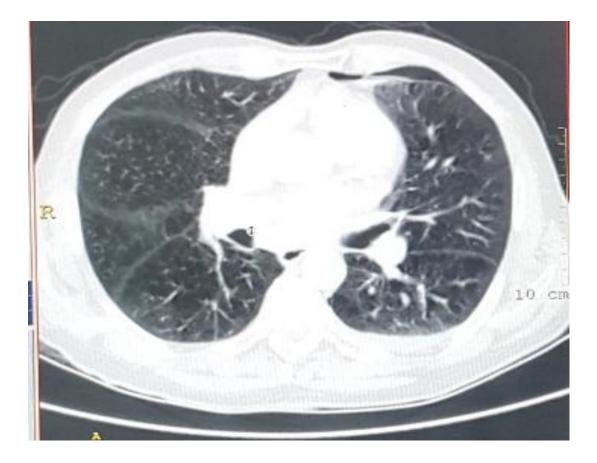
Post biopsy CT chest of a 74 year old male chronic smoker showing a small left sided post biopsy pneumothorax which resolved spontaneously on subsequent follow up
